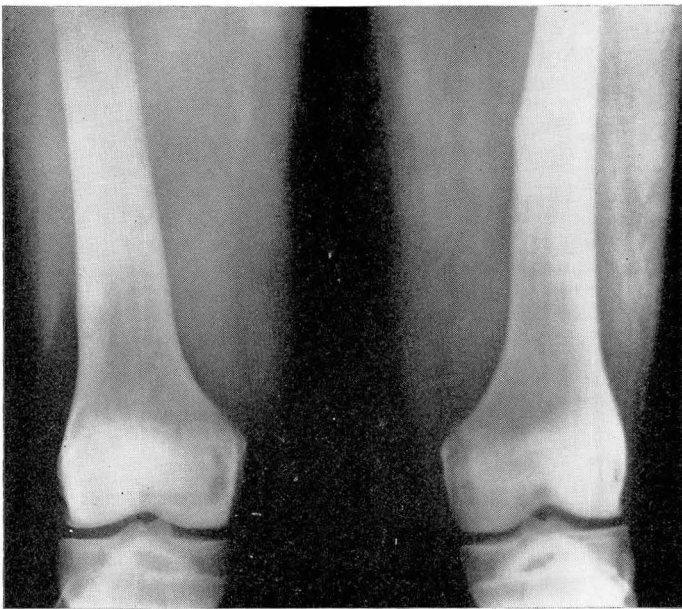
Roentgenogram of the distal femur showing metaphyseal clubbing.
